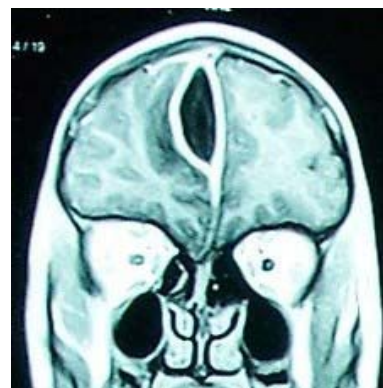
Contrast enhanced MRI scan coronal section showing interhemispheric subdural empyema in anterior one third region.
